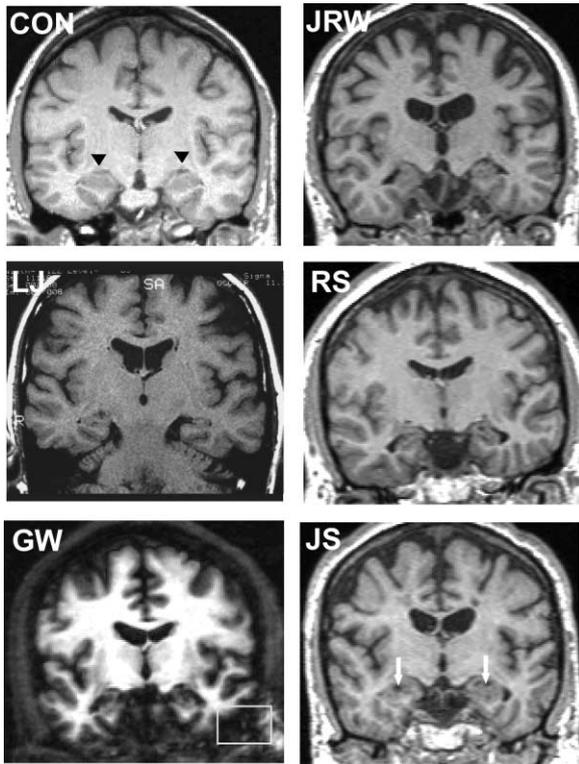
Magnetic Resonance Images for Five of the Six Amnesic Patients with Damage Limited Primarily to the Hippocampal Region and a Healthy Control
